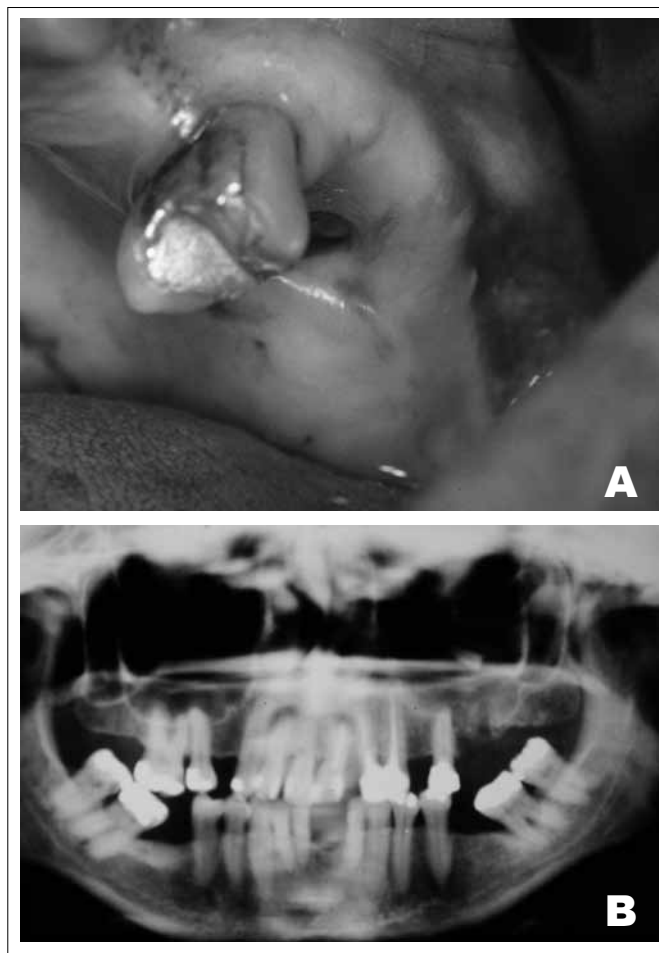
A. Intraoral evaluation the presence of oro-sinus fistula was observed in the alveolar ridge in the region of 26. B. Radiographs panoramic was observed the presence of an image compatible with a root inside the left maxillary sinus.
